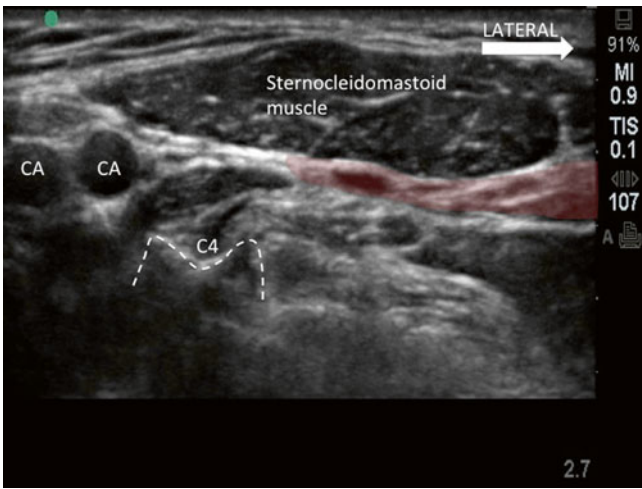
Sonogram of the superficial cervical plexus (shaded with purple color) at the level of C4. Multiple nerves in short axis are seen sequestered in this space deep to the sternocleidomastoid muscle. CA, carotid artery, which bifurcates into internal and external carotid arteries (Reproduced with permission from Philip Peng Education Series)
